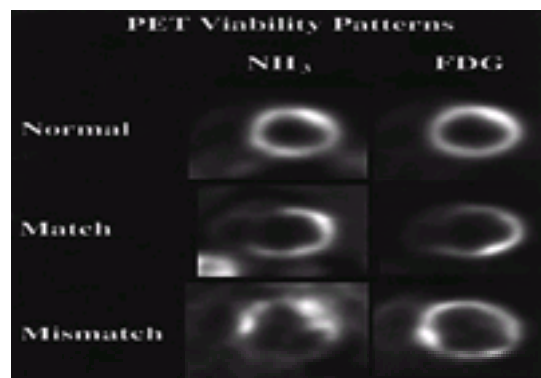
PET imaging patterns of myocardial blood flow and metabolism for assessing myocardial viability. The blood flow was assessed using ^{13}N ammonia as a perfusion tracer and the glucose metabolism using ^{18}F fluorodeoxyglucose (FDG). Representative short-axis tomograms are shown for three glucose-loaded patients. Upper panel: The left ventricular (LV) myocardium from a normal patient shows a homogeneous distribution of the perfusion (NH_3) and metabolism (FDG) tracers. Middle panel: The LV myocardium from a patient with a transmural myocardial infarction of the septum shows a marked matched reduction of septal uptake by both tracers. Lower panel: The LV myocardium from a patient with a hibernating inferior wall shows a marked reduction of perfusion (NH_3) with a mismatched normal metabolic uptake of FDG.
